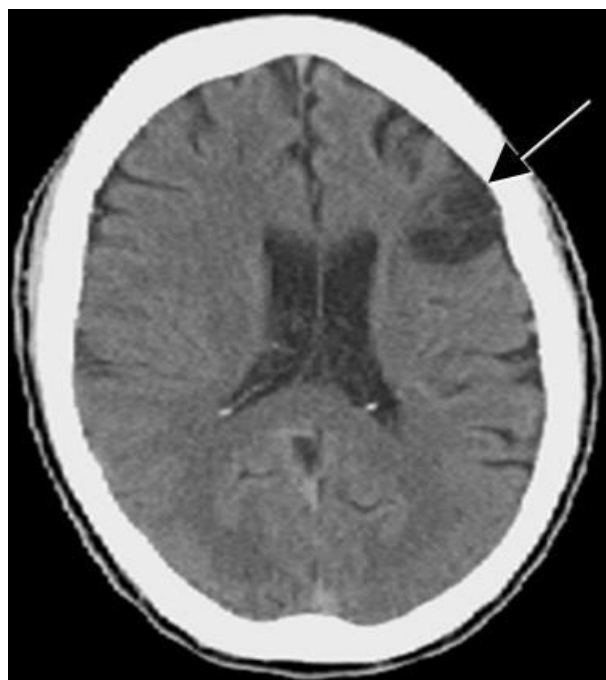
Axial CT scan of brain without contrast. Area of old ischemic infarction involving the left frontal region (arrow).
